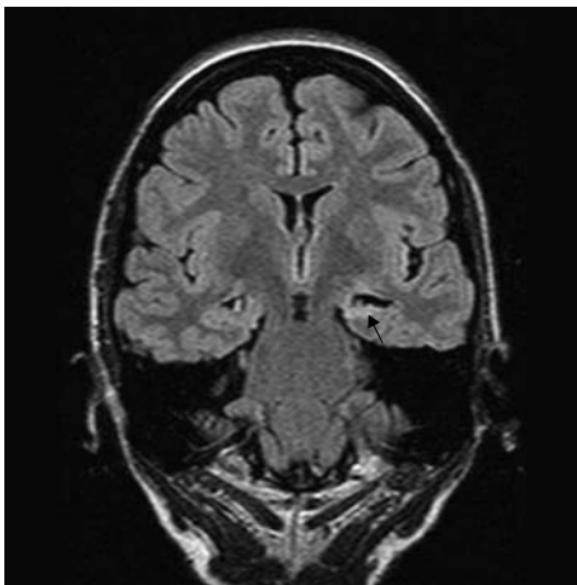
Hippocampal sclerosis. (a) Thin section gradient echo T1-weighted volume and (b) thin section coronal FLAIR MRI. Typical reduction in volume (white arrowheads) and hyperintensity (black arrow) of the left hippocampus.
